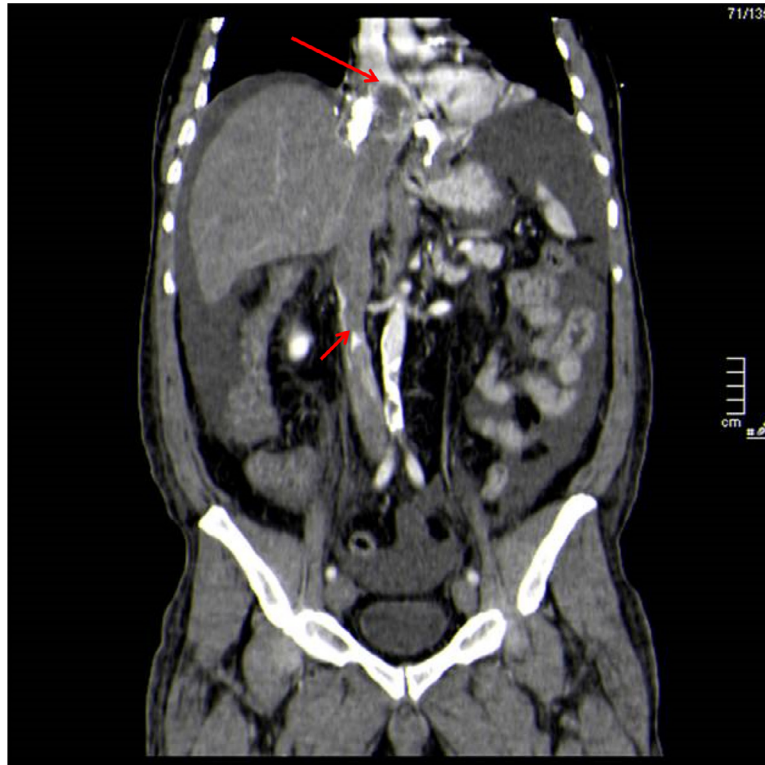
Abdomen/pelvis CT coronal reformat demonstrating thrombus extending from the right atrium (long red arrow) inferiorly to the level of the infra-renal inferior vena cava (short red arrow). Dense accumulation of intravenous contrast within the right atrium.
